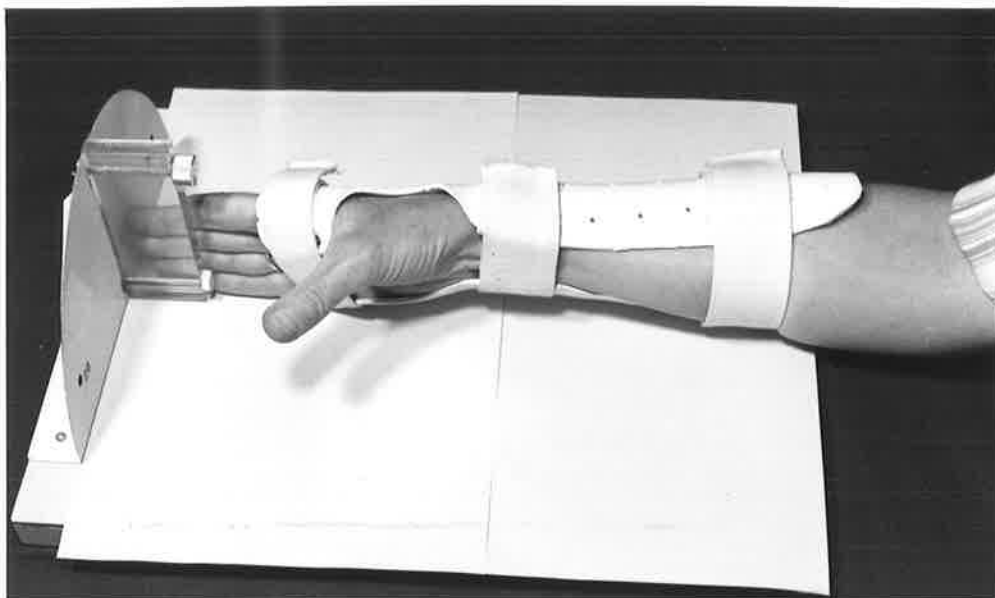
Position of right hand for radiographic measurement of palmar-abduction.
